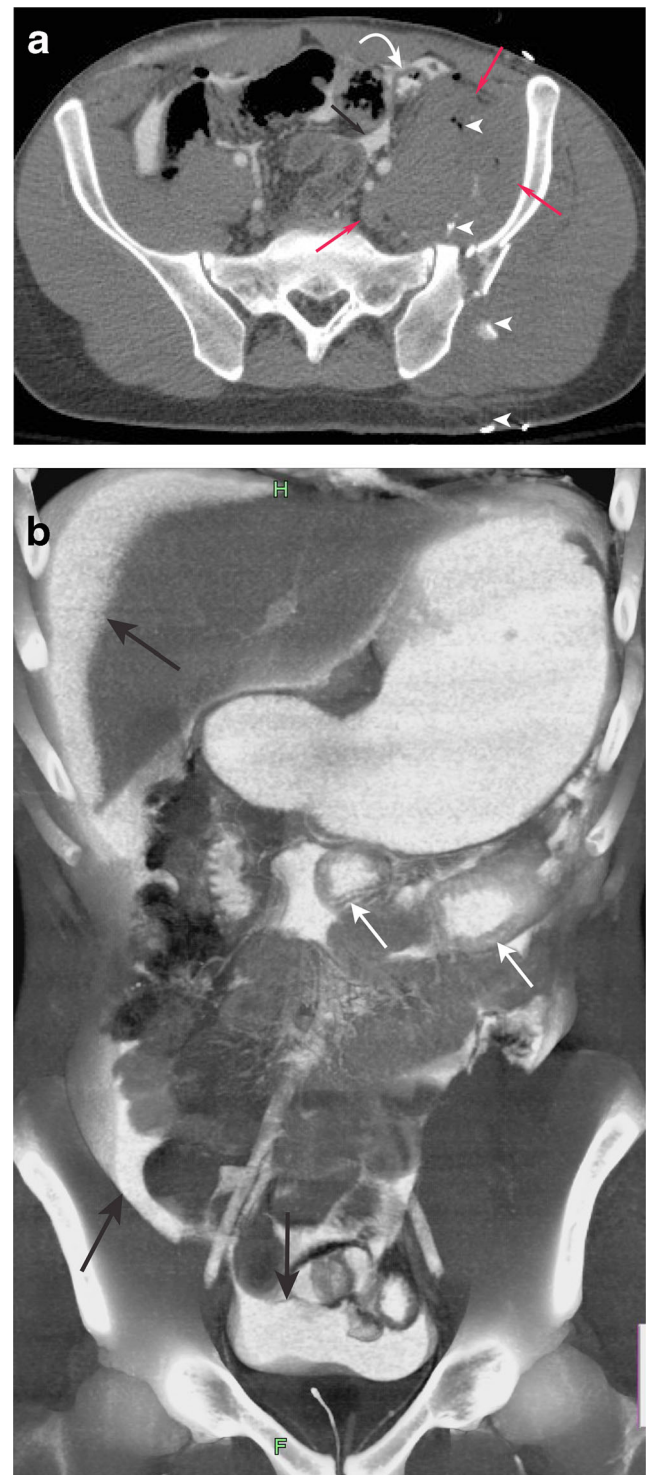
Gunshot wound to left pelvis with rectal contrast material extravasation. a. Axial and b. Coronal reformat CT images demonstrate a wound tract (arrowheads) outlined by hematoma, bullet and bone fragments. There is both descending colon (curved arrow) and jejunal wall (white arrows) thickening. Rectal contrast material (black arrow) extravasation is seen throughout the peritoneum
